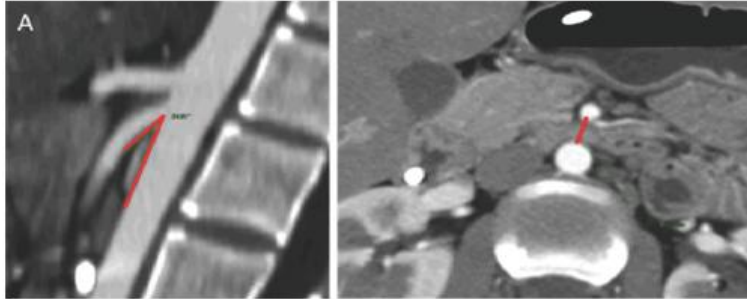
Follow-up computed tomography for patient 1. A and B. Increase in the aorto-mesenteric angle and distance from 23 and 7.4 mm, respectively (red lines).
